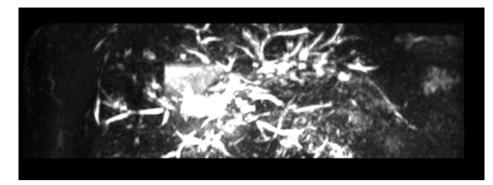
MR image of a patient with PSC (from Istanbul Medicine Faculty Hospital Gastroenterohepatology department archive, to be taken with the consent of the patient). PSC, primary sclerosing cholangitis.
